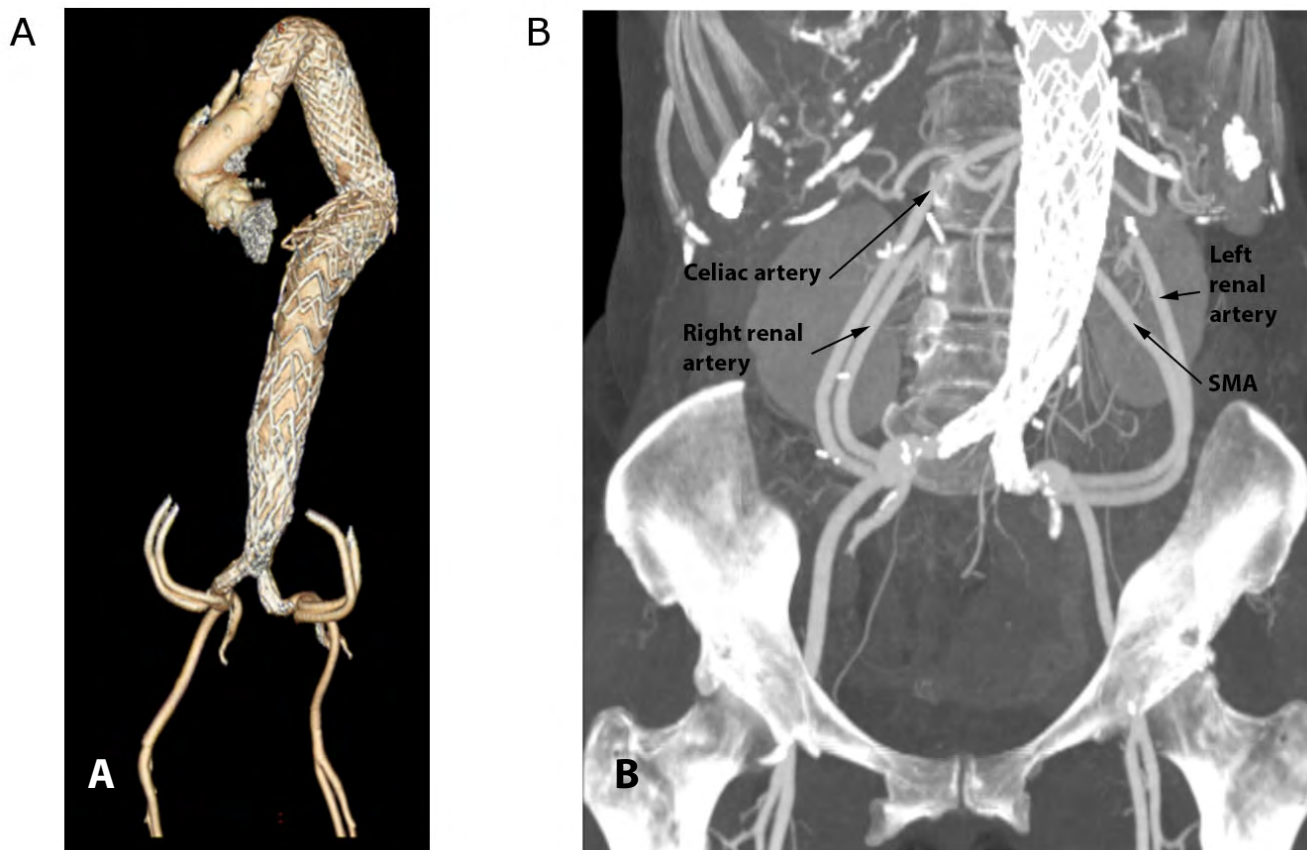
Three-dimensional reconstruction (A) and maximum intensity projection images (B) of follow-up CTA, demonstrating excluded aneurysm and patent ilio-mesenteric and ilio-renal bypasses.
